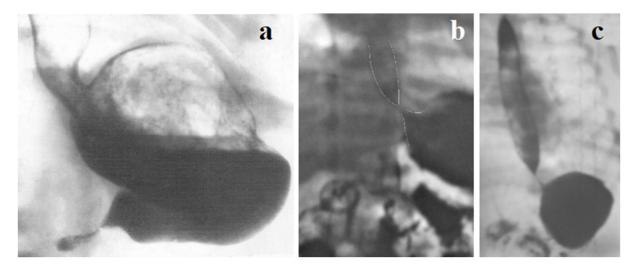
The radiographs of the EGJ of restless babies with x-ray evidence of GERD. (a) Liquid level in the stomach above the barium level and level in the esophagus. The LES opened but the body of the stomach is not expanded, and the contracted antrum is located below the gastric body, which excludes pyloric stenosis. (b) The abdominal part of the LES is opened and reflux into the esophagus is visible. (c) In a horizontal position, abdominal compression caused the LES to contract. There is no peristalsis in the esophagus between the upper and lower sphincters.
